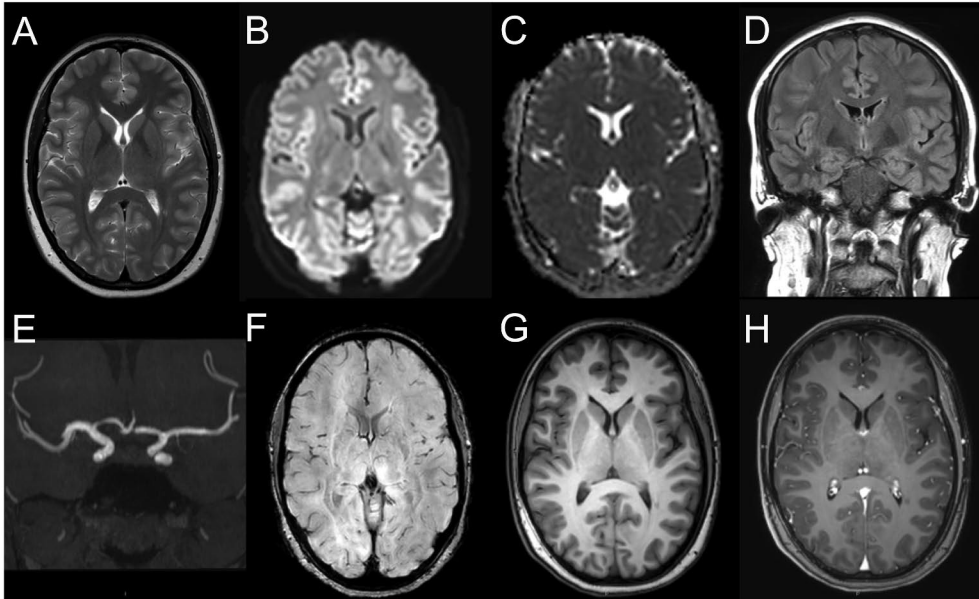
Example demonstrations of brain MRI sequences. Sequences are: T2 axial (A), DWI trace axial (B), DWI ADC (apparent diffusion coefficient) axial (C), FLAIR coronal (D), TOF-MRA MIP (maximum intensity projection) coronal (E), SWI axial (F), T1 3D TFE (turbo field echo) axial (precontrast) (G), and T1 3D TFE axial (postcontrast) (H).
